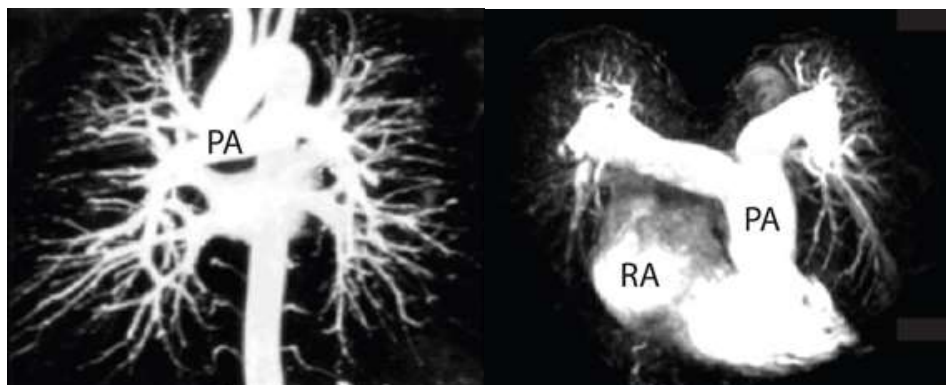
MRI angiograms of chest. Left: healthy person. Right: PAH patient showing obliterated distal pulmonary arteries, pressure over-loaded proximal pulmonary arteries and distended right-heart. PA = pulmonary artery, RA = right atrium. Adapted from Sutendra and Michelakis (2013).
